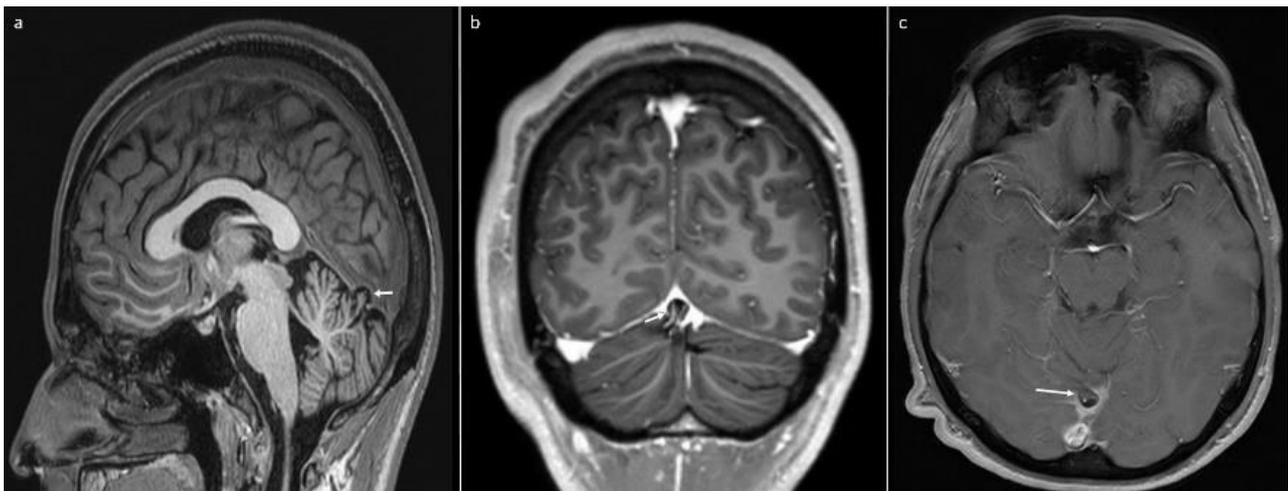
24-year-old-man with seizure. a. Sagittal 3D T1 FFE image shows left cerebellar parenchymal herniation into the torcula (arrow). b, c. Contrast-enhanced 3D T1-weighted GRE coronal and contrast-enhanced T1-weighted FFE axial MR images also depict cerebellar herniation into the torcula (FFE: Fast field echo, GRE: Gradient echo, MR: Magnetic resonance)
